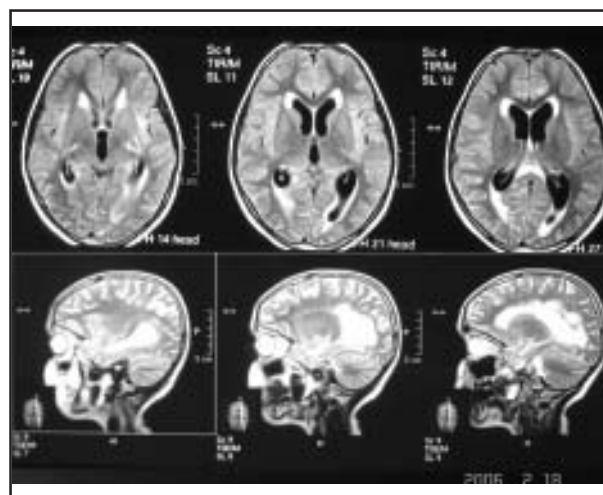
Brain MRI showed patchy hyperintense areas
